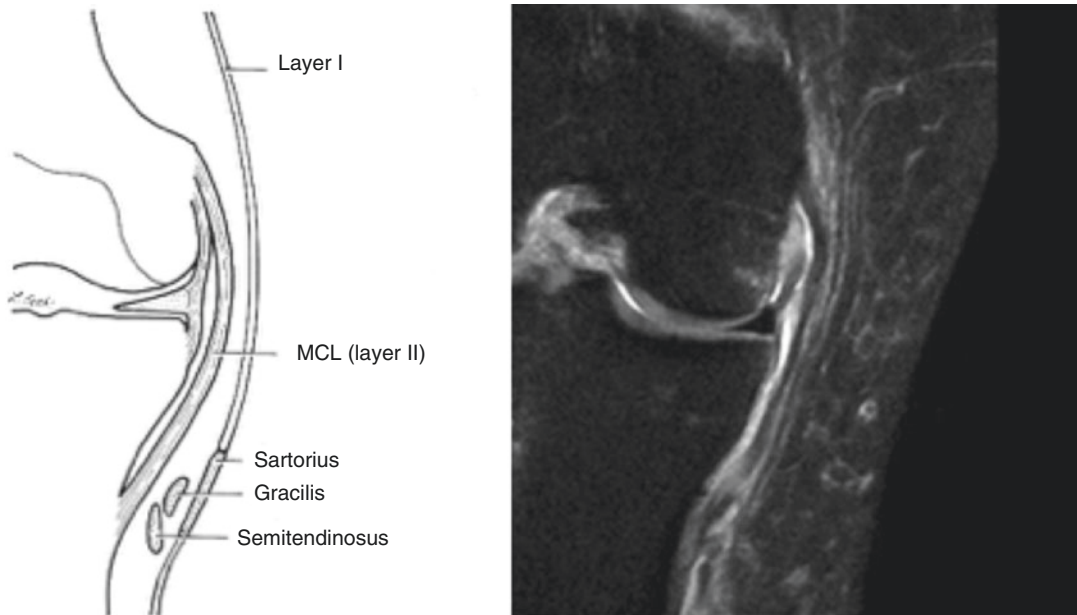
The three layers of supporting structures on the medial side of the knee can be visualised on MRI
